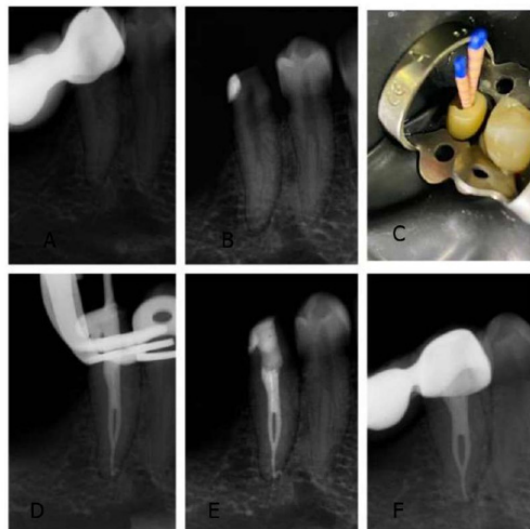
A. Initial radiography; B. After crown removal; C. Root canal obturation; D. Radiography after obturation; E. Coronal seal; F. Porcelain crown.
